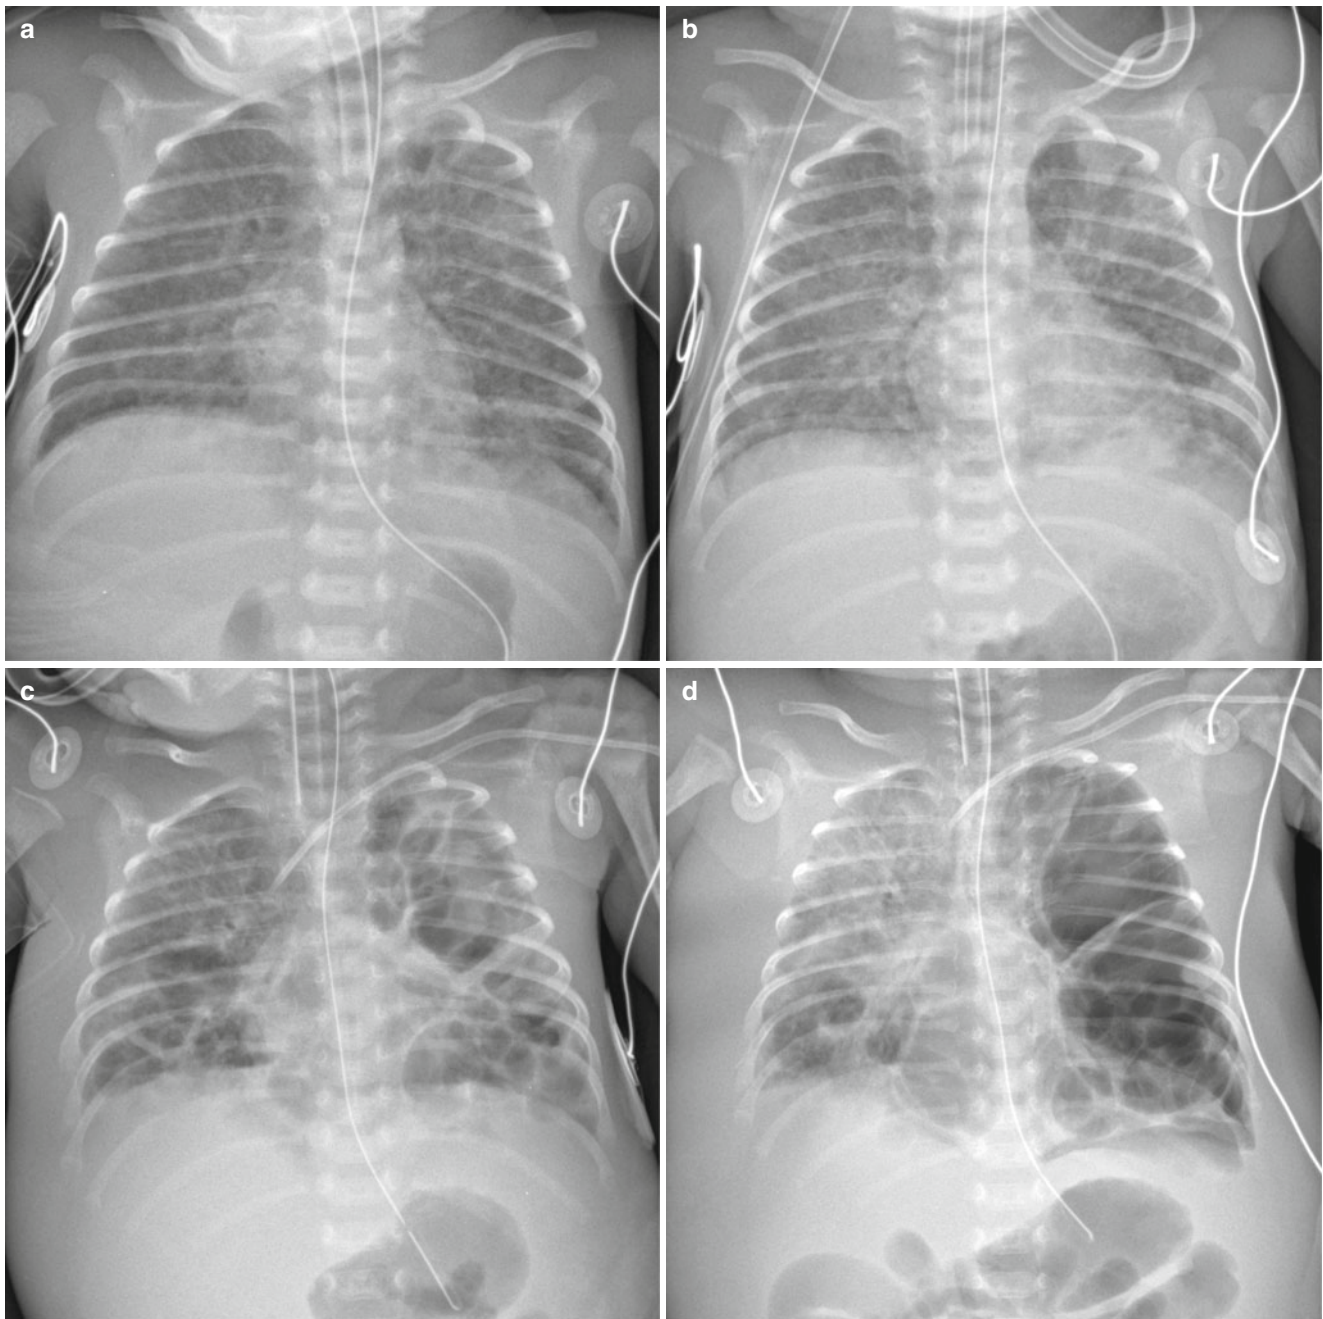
Staphylococcus aureus* pneumonia in a 32-week-gestational-age newborn. (a) Anteroposterior radiograph obtained at 10 days of age demonstrates diffuse uniform reticular opacities, suggestive of bronchopulmonary dysplasia. (b) Two days later, follow-up chest radiograph reveals irregular patchy infiltrates in both lungs. From that time, blood cultures were positive for methicillin-resistant *Staphylococcus*
